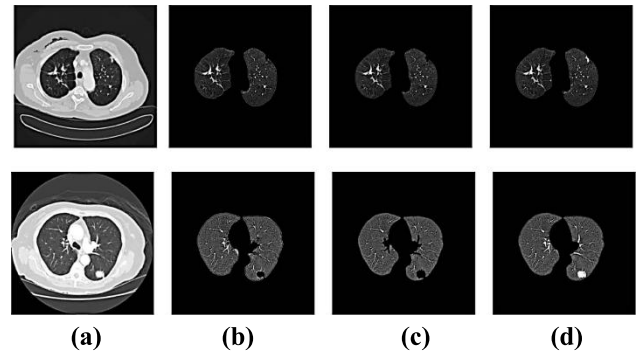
Comparison of segmentation outcomes for all the grades (a) Computed Tomography images (b) segmentation established by region growing (c) Lung segmentation established by Modified K-means clustering algorithm (d) Lung segmentation established by AHHMM approach.
